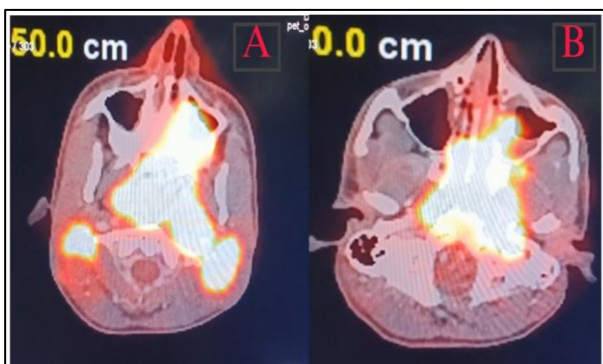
(A and B): PET CT-large ill-defined hypermetabolic space occupying soft tissue lesion involving nasopharynx, extending to posterior nasopharynx, left lateral nasopharyngeal wall and oropharynx with hypermetabolic cervical lymphadenopathy.
